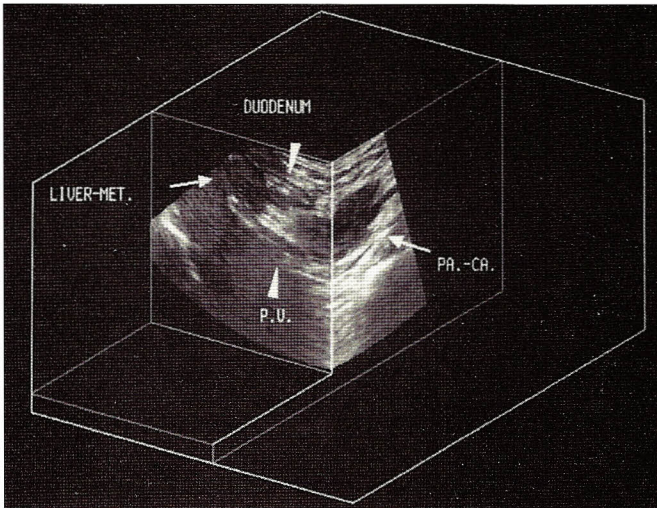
Abdominal 3-D ultrasound of pancreatic carcinoma (Volume display). (P.V. = portal vein)
